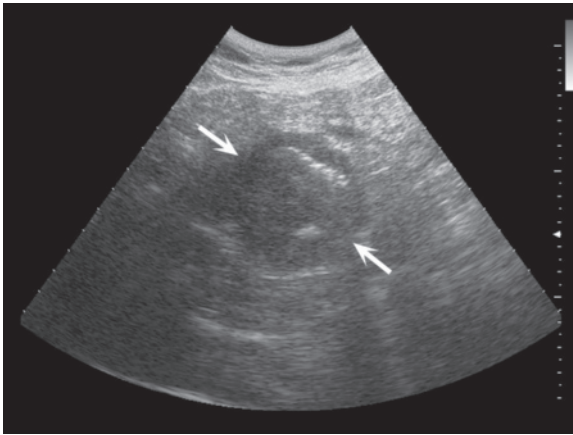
c Intestinal and mesenteric lymphoma. Multiple enlarged mesenteric lymph nodes (a) associated with dilatation of an ileal loop with diffusely thickened walls (b). Coronal CT reconstruction confirms both the mesenteric and retroperitoneal adenopathies (short arrow) and the “aneurysmal” dilatation of the ileal loop (c, long arrow)
